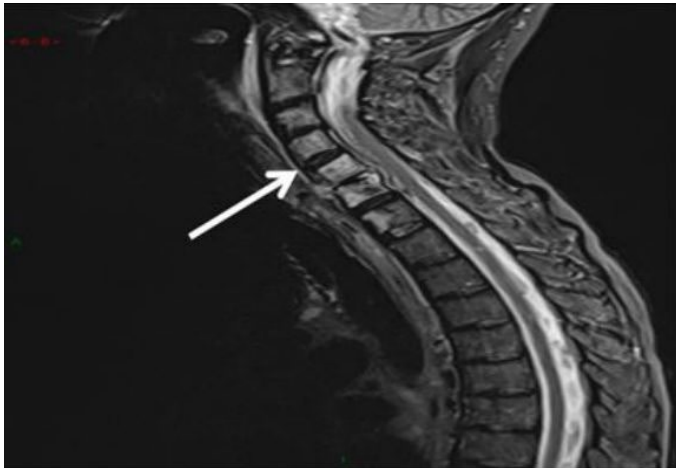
Spondylodiscitis confirmed by cervical MRI.
